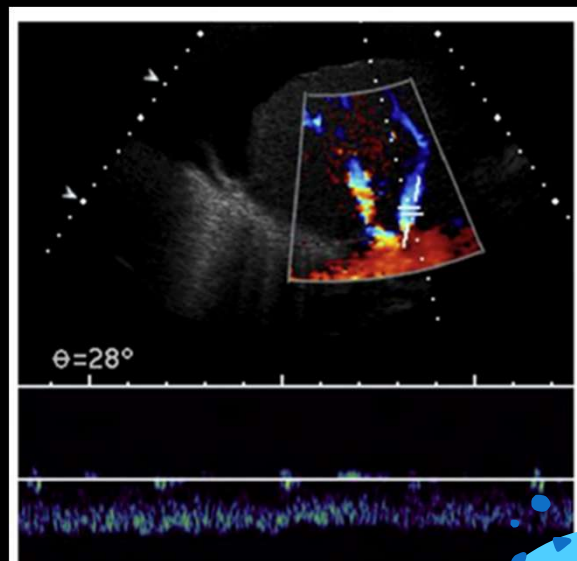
Color and spectral Doppler of hepatic vein demonstrating blunted flow.
